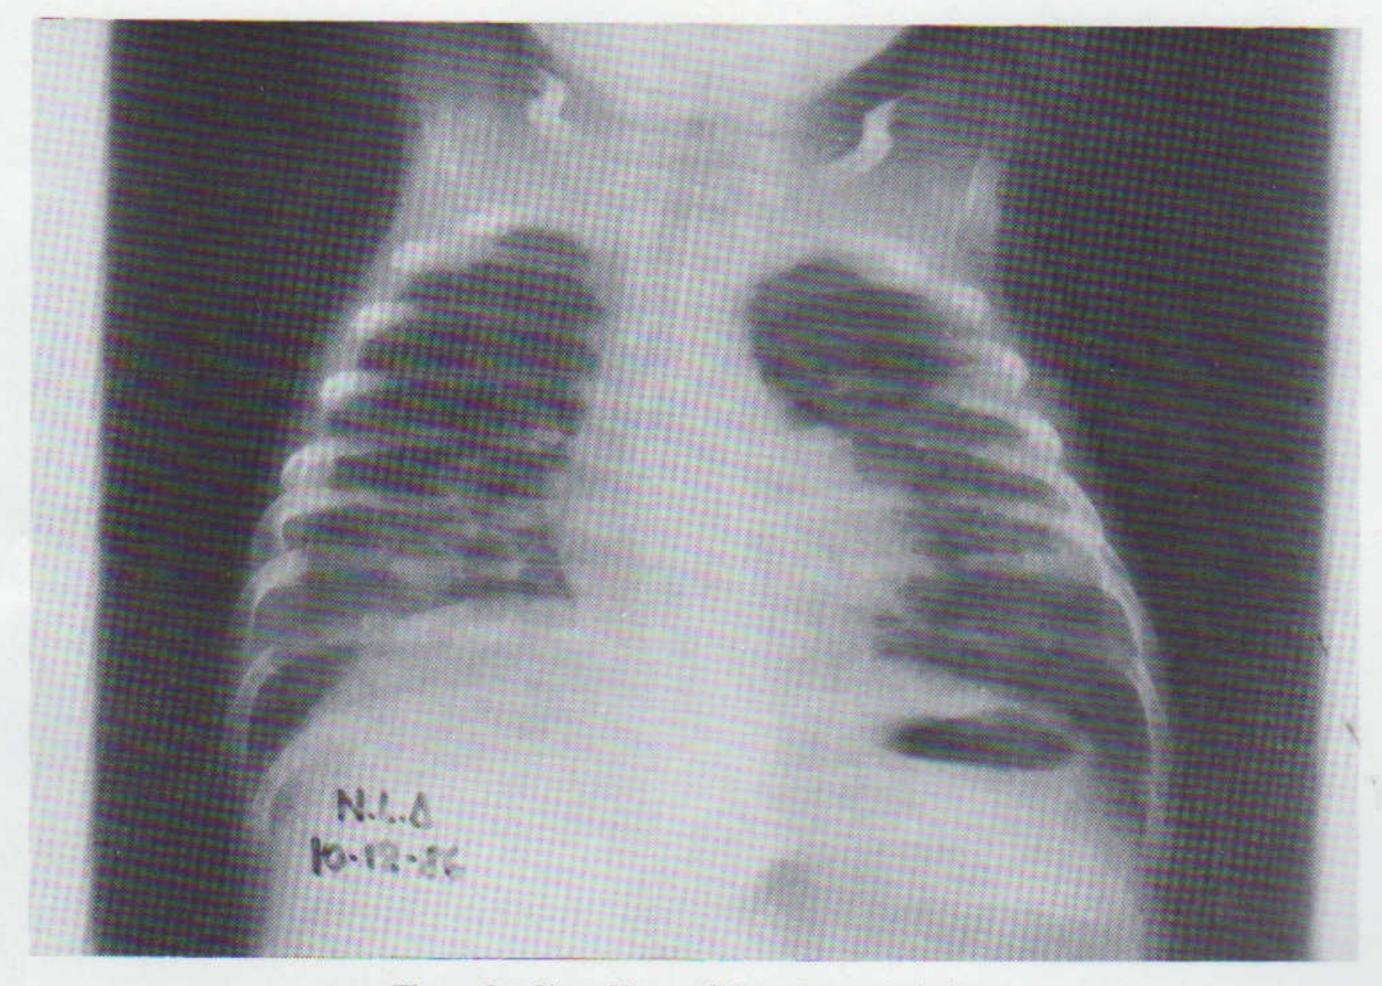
Chest X-ray of Case 2 on admission.
